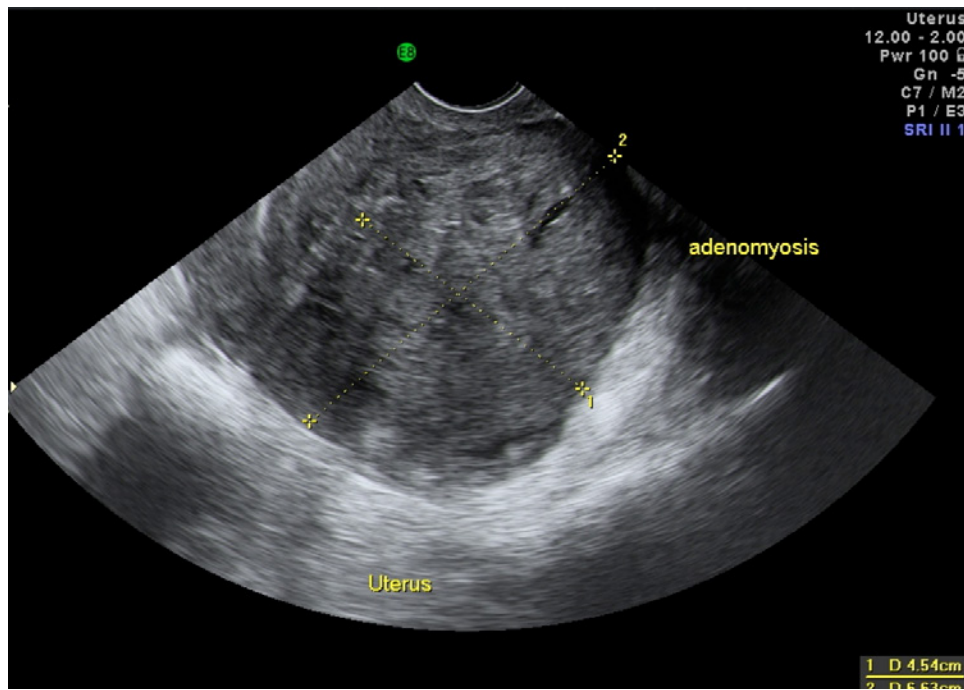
Ultrasound showing a posterior adenomyoma
